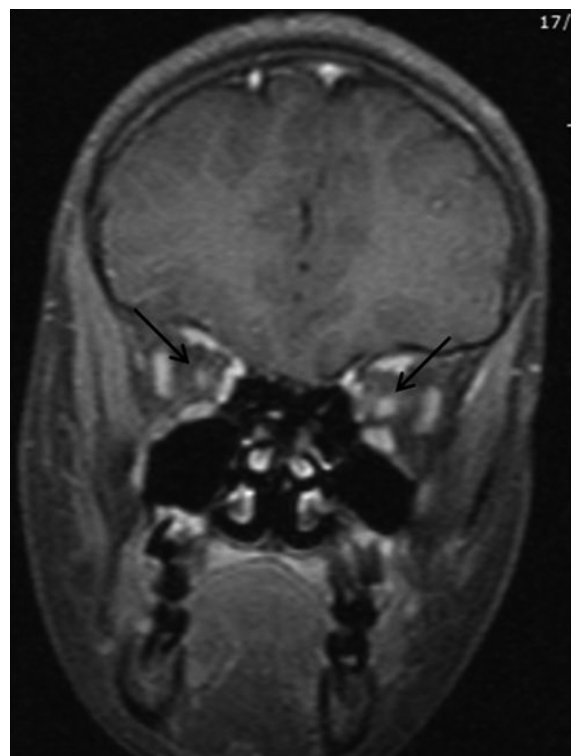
Fat-saturated post-contrast T1-weighted axial (2a) and coronal (2b) images of the orbits show bilateral optic nerve enhancement.
